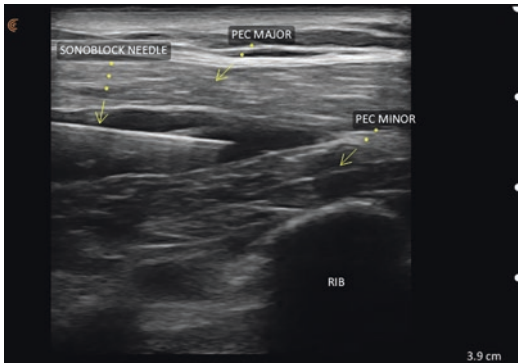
Grayscale ultrasound image of chest wall showing an increased size of the anechoic space separating the pectoralis major and minor muscles
